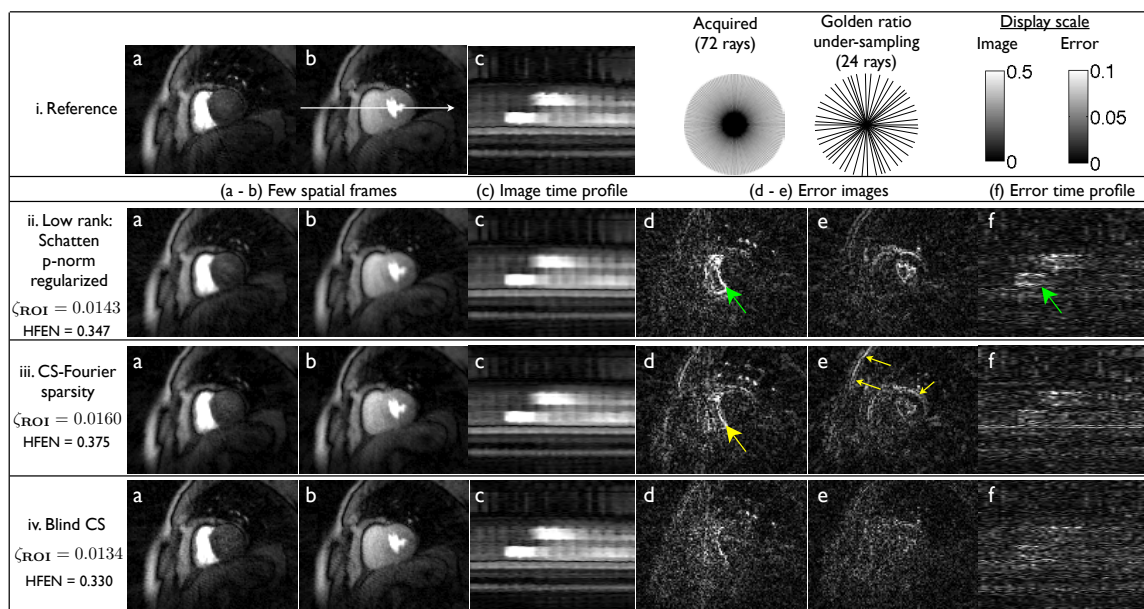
Comparisons of different reconstruction schemes on a stress myocardial perfusion MRI dataset with breathing motion: Retrospective sampling was considered by picking 24 radial rays/frame from the acquired 72 ray data; the rays closest to the golden ratio pattern was chosen. Few spatial frames, the corresponding image time profile, error frames, and error in image time profile are shown for all the schemes. We specifically observe loss of important borders and temporal blur with the low rank and CS schemes while the blind CS reconstructions have crisper borders and better temporal fidelity. Also note from the columns d,e,f that the errors in the BCS scheme are less concentrated at the edges, compared to the other methods. This indicates that the edge details and temporal dynamics are better preserved in the BCS reconstructions.
